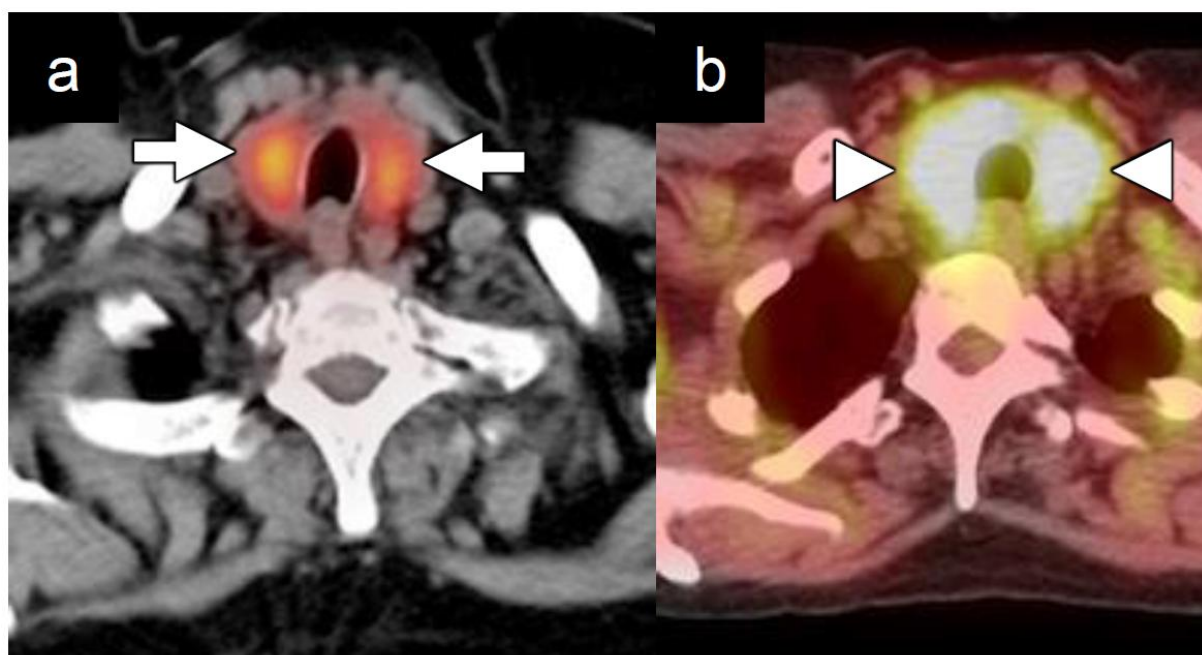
Incidental symmetric, diffusely increased thyroid FDG uptake. Fused axial FDG-PET/CT (a) in a patient with Hodgkin lymphoma demonstrates diffuse mildly increased thyroid gland FDG uptake (white arrows). The patient's history and laboratory values were compatible with subclinical hypothyroidism. Fused axial FDG-PET/CT (b) in different patient with a history of Hodgkin lymphoma demonstrates significant diffuse thyroid gland uptake (white arrowheads). The patient's history and laboratory values were also compatible with hypothyroidism.
